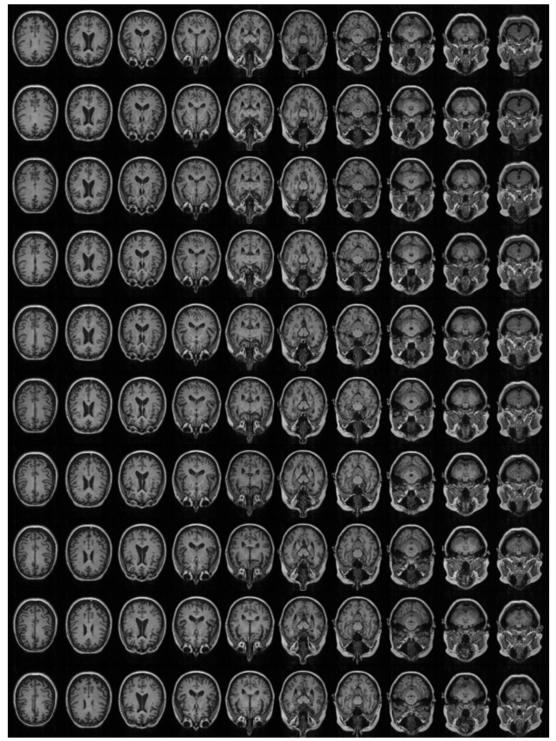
Axial view of 3D MRI of brain
